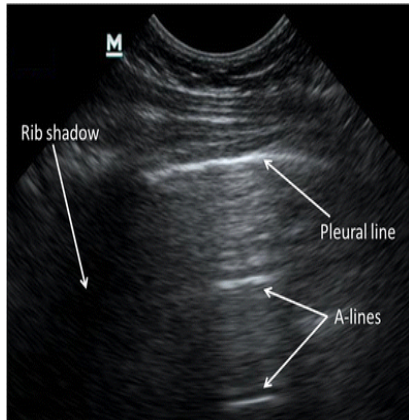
Normal Ultrasound in children : note the A lines
